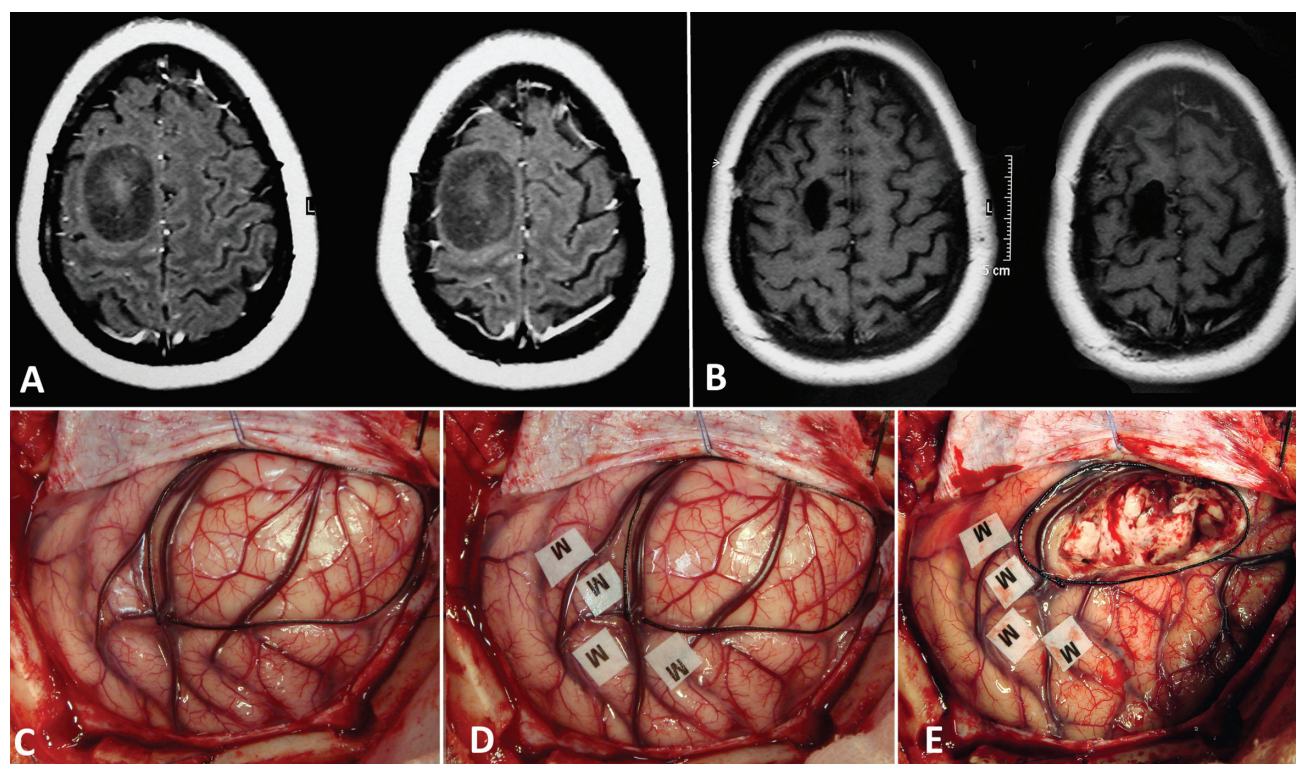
(A) Preoperative, contrast-enhanced T1-weighted MRI: Hypointense, fairly enhancing, slightly insufflated image located in the right frontal region whose posterior border is close to or encompassing the motor area. (B) Postoperative, contrast-enhanced MRI showing complete lesion resection. (C) Intraoperative photo: Wide craniotomy with exposure of the cortex infiltrated by the disease and a silk thread demarcating the planned resection area. (D) Intraoperative photo after mapping: motor cortex (M) is outside the planned resection area. (E) Intraoperative photo: final appearance after tumor resection, demonstrating that initially planned surgical strategy was performed without the influence of cortical stimulation.
